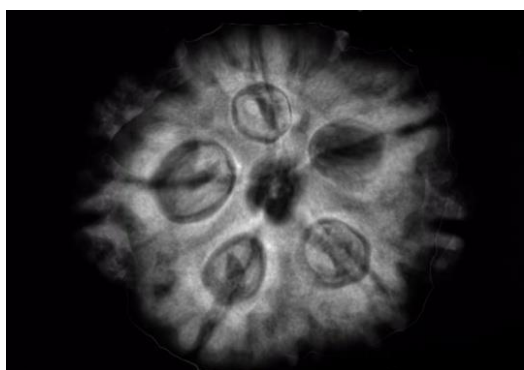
X-Ray analysis of Rudraksha seed showing genuine five face.
